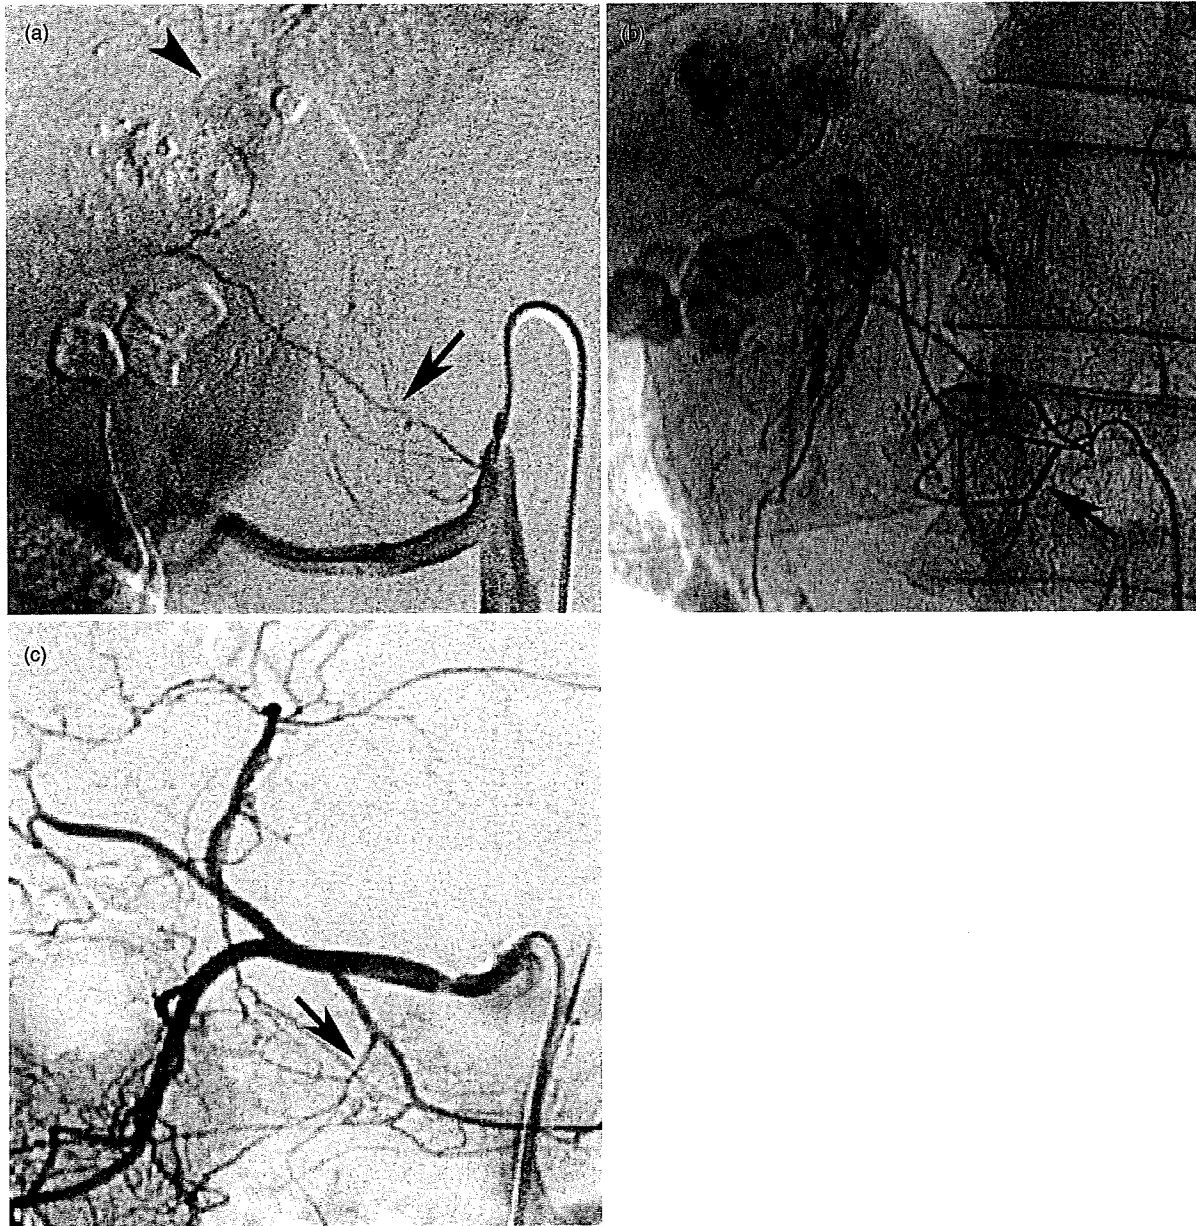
(a) Arteriogram shows that a tumour (arrowhead) is fed by the right middle adrenal artery arising from the aorta (arrow). (b) Spot radiograph obtained during transcatheter chemoembolisation shows a vessel that is not seen in (a) (arrow). (c) Arteriogram of the common hepatic artery reveals that the vessel is the dorsal pancreatic artery derived from the common hepatic artery (arrow).
